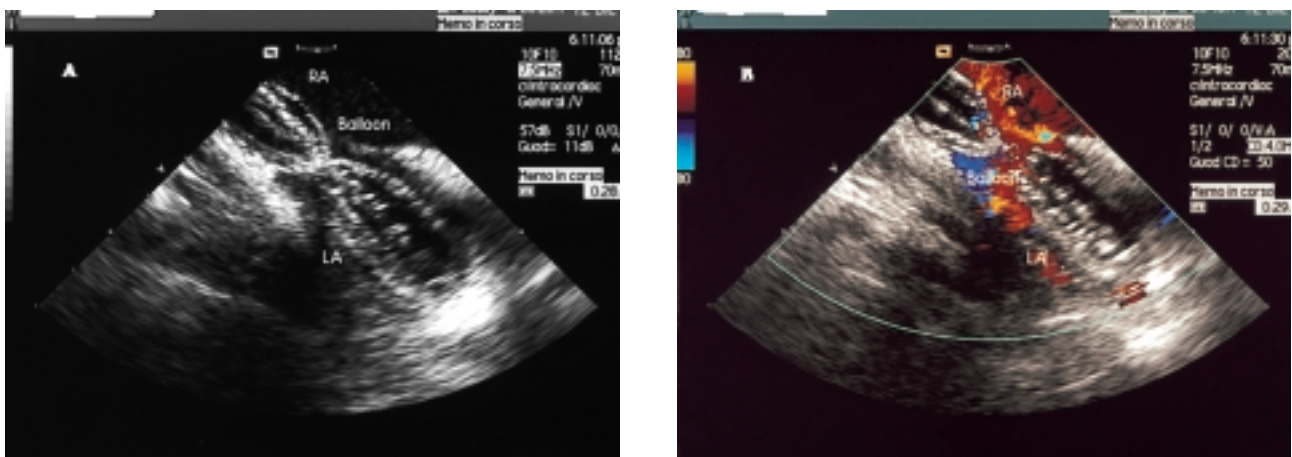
Intracardiac echocardiography shows the inflated sizing balloon occluding the two adjacent defects (A). Color Doppler shows the persistence of a residual shunt originating from a third one (B). LA = left atrium; RA = right atrium.
